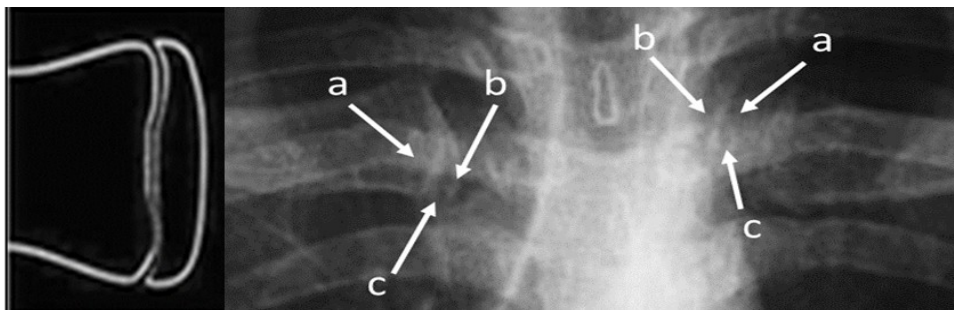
Radiograph of a 24-year-old patient shows stage 3 ossification: the estimated age = 24 years. a — epiphyses, b — bone tubercle closing the gap between epiphyses and metaphysis, c — metaphysis.
